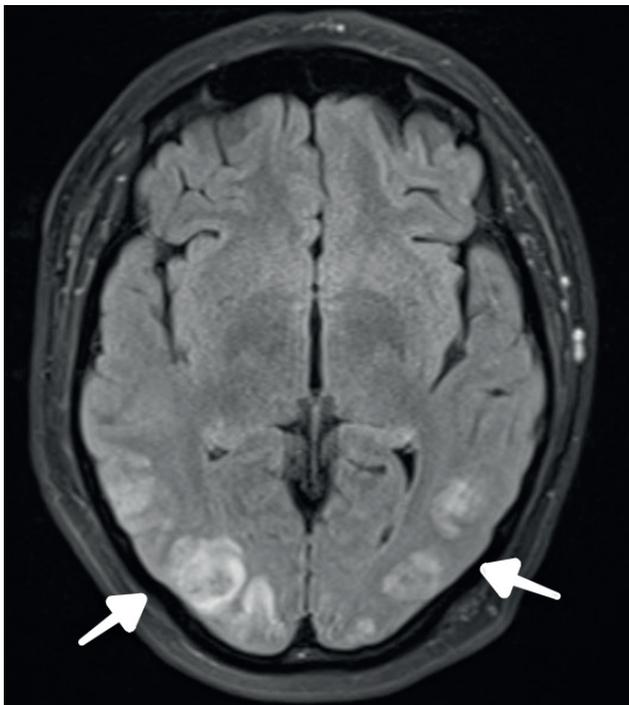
Vasogenic edema on MRI. Axial T2-FLAIR MRI image here demonstrating hyper-intensity foci in the bilateral parietal and occipital lobes, which are characteristic distribution of vasogenic edema in PRES with likely involvement of posterior cerebral artery circulation.
